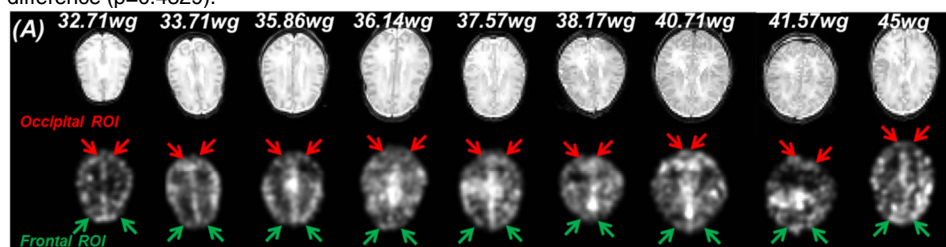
Regional CBF dynamics with ROI analysis. (A) T2-weighted image (upper) and corresponding CBF map (lower) of each subject; (B) Relationship of regional CBF values and gestation ages. Red and green arrows in (A) indicate the occipital and frontal ROIs, respectively.
